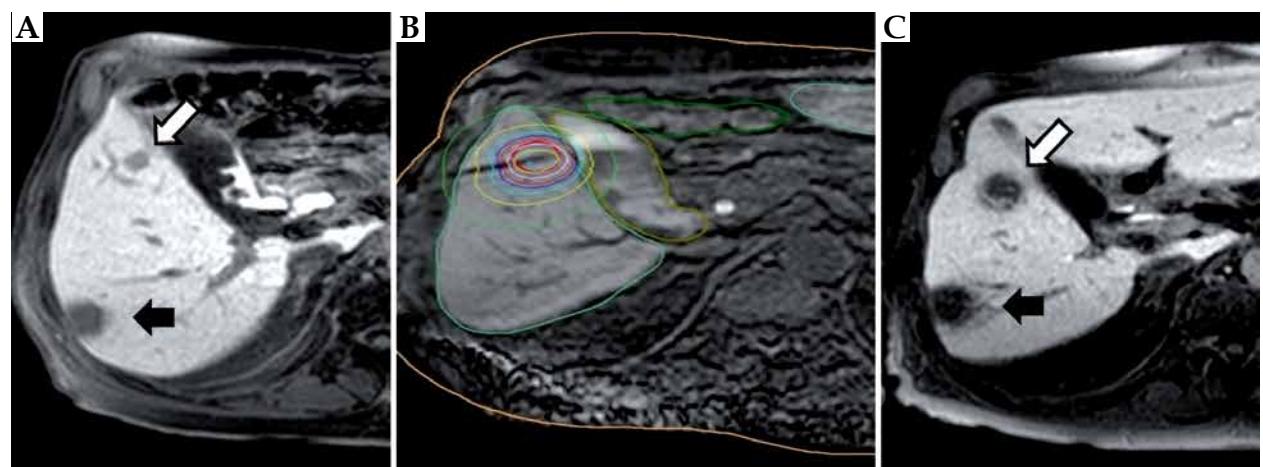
A) Gd-EOB-DTPA enhanced T1w MRI of a patient with liver metastasis from esophageal squamous cell carcinoma and sequential treatment with interstitial high-dose-rate brachytherapy (HDR IBT = IBT). White arrow indicates lesion planned for IBT and black arrow shows characteristic Gd-EOB-DTPA enhancement defect after irradiation of a metastases 2 weeks before; B) Planning MRI with marked target lesion (red line), isodose lines, and catheters; C) 3 months follow-up: white arrow indicate lesion treated with Gd-EOB-DTPA enhancement defect and black arrow indicate first treated lesion with constant Gd-EOB-DTPA enhancement defect after IBT
